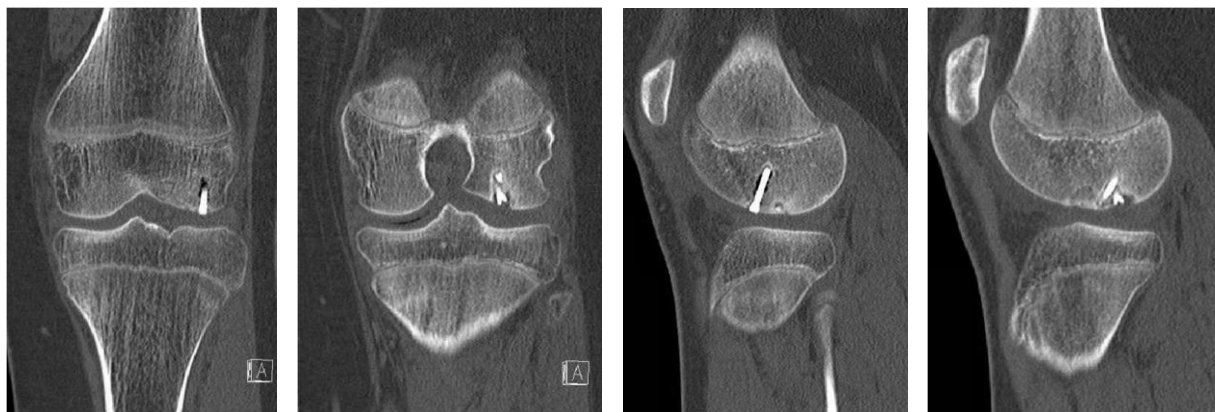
CT scan 6 month post operative presenting a healed osteochondral flap with minor gas formation surrounding the resorbable screws.
